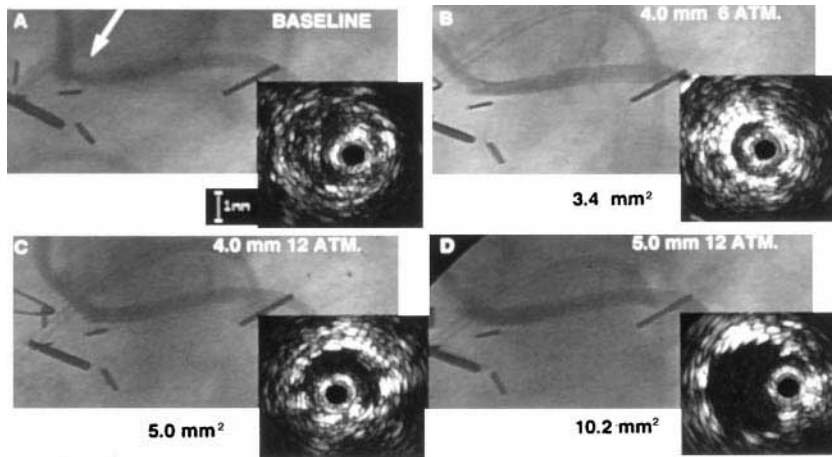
The baseline study reveals an ostial stenosis of a saphenous vein graft that is significant both by angiography as well as by ultrasound. Following inflation of the stent with a 4-mm balloon at 6 atm (which at the time was the recommended pressure) the angiographic result is significantly improved; however, the ultrasound cross-sectional lumen area was only 3.4 mm². By using higher pressures (12 atm) with the same balloon we were able to increase the dimensions to 5 mm². By using a larger balloon and higher pressure the final result was 10.2 mm². This use of IVUS-guided stent deployment increased the residual lumen cross sectional area 300% from 3.4 to 10.2 mm².
